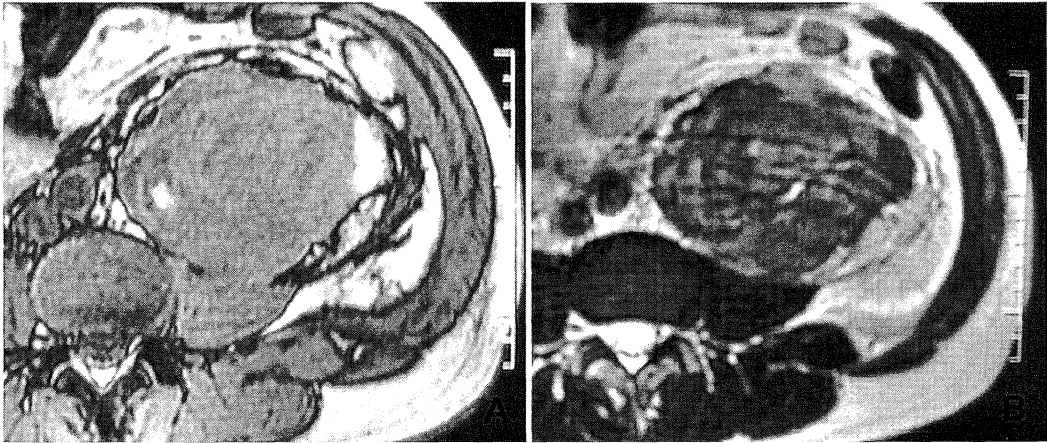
MR imaging at the first admission.
